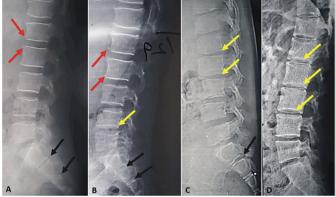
Lateral radiographs showing anterior osteophytes (red arrows) disc height loss (yellow arrows) and non-fusion of sacral vertebrae (black arrows) in (A) a 24-year-old male (B) a 31-year-old male (C) a 20-year-old male and (D) a 21-year-old female. Note the loss of lumbar lordosis in C & D.
